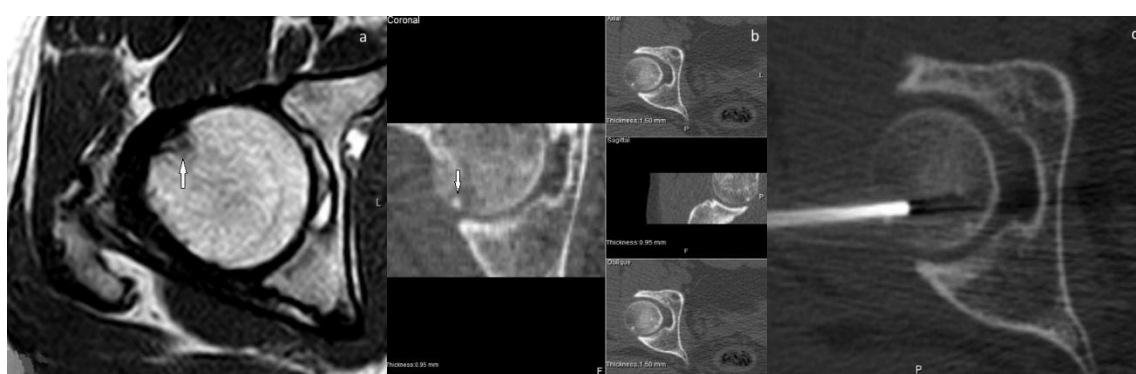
A 27-year-old male patient with chronic hip pain. (a) (Axial TSE T1 MR), (b) (thin-slice, non-contrasted axial and other plans reformatted CT), (c) (Percutaneous CT-guided radiofrequency ablation in axial plane) images show intra-articular osteoid osteoma in the anterior superior femoral head (white arrow). RF—Radiofrequency ablation, MR—Magnetic Resonance, CT—Computerized Tomography.
